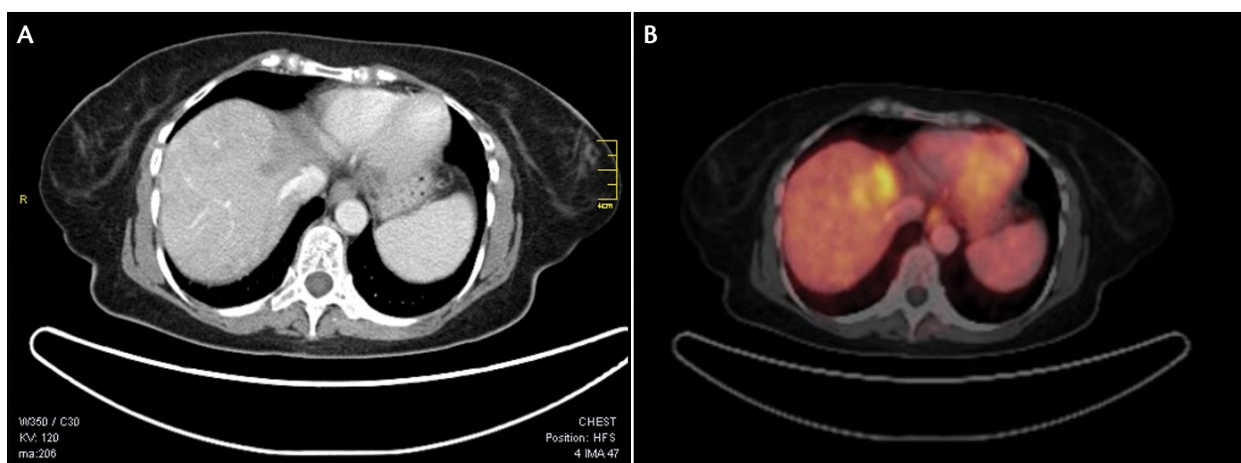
Axial contrast-enhanced CT (A) and axial-fused FDG PET/CT (B) after radioembolization show partial response, with reduction in size and reduction in hypermetabolism associated with the treated lesion.
